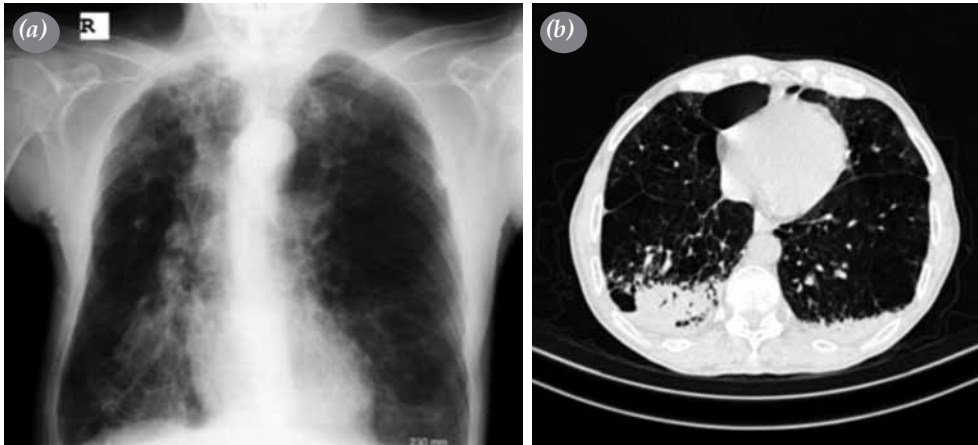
A chest X-ray and computed tomography scan showing (a) consolidation and (b) significant infiltrations in the right lung.
